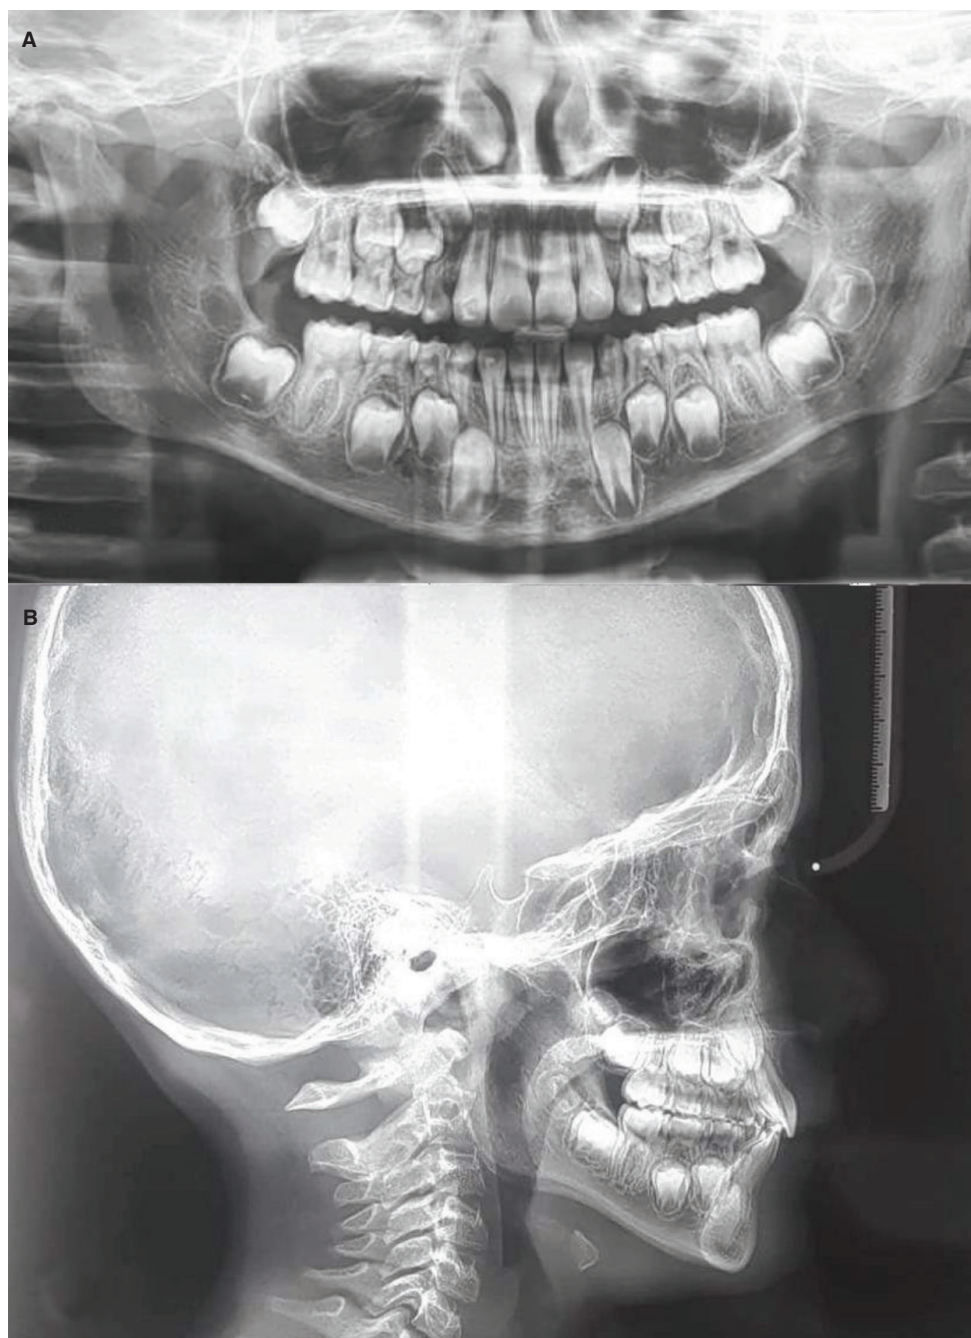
Panoramic radiography (A) and lateral cephalometric radiography (B) after the treatment.
